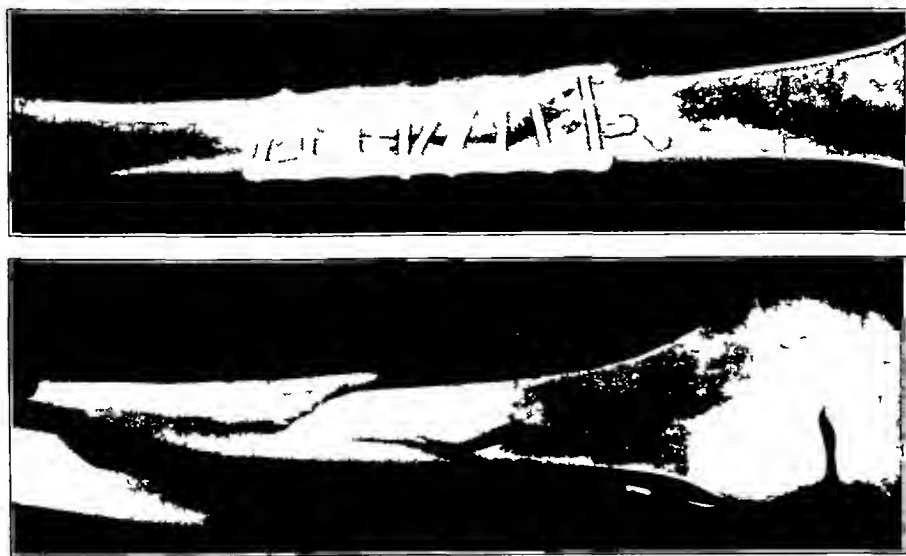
Case 2 Radiograph of the right femur, showing a segmental fracture which occurred May 31, 1946
